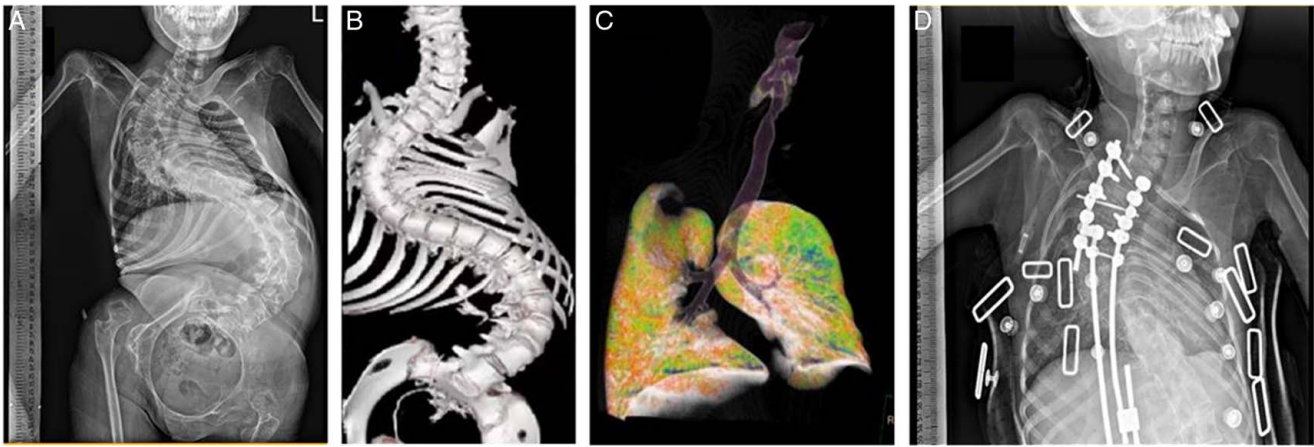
Typical case 1 A 12-year-old female spinal muscular atrophy patient with type II, whose Cobb's angle (coronal plane) was 145° for lumbar spine and 136° for thoracic spine (A, B). Preoperative three-dimensional airway reconstruction showed a little atelectasis in the right upper lobe and left lower lobe (C). Pulmonary function showed a severe restrictive ventilatory dysfunction (FVC was 32% of predicted and FEV1 was 25.2% of predicted). She underwent posterior scoliosis correction under general anaesthesia and admitted to ICU with endotracheal tube and extubated at 21 h. After extubation, chest radiograph showed significant improvement of thoracic deformity (D).
